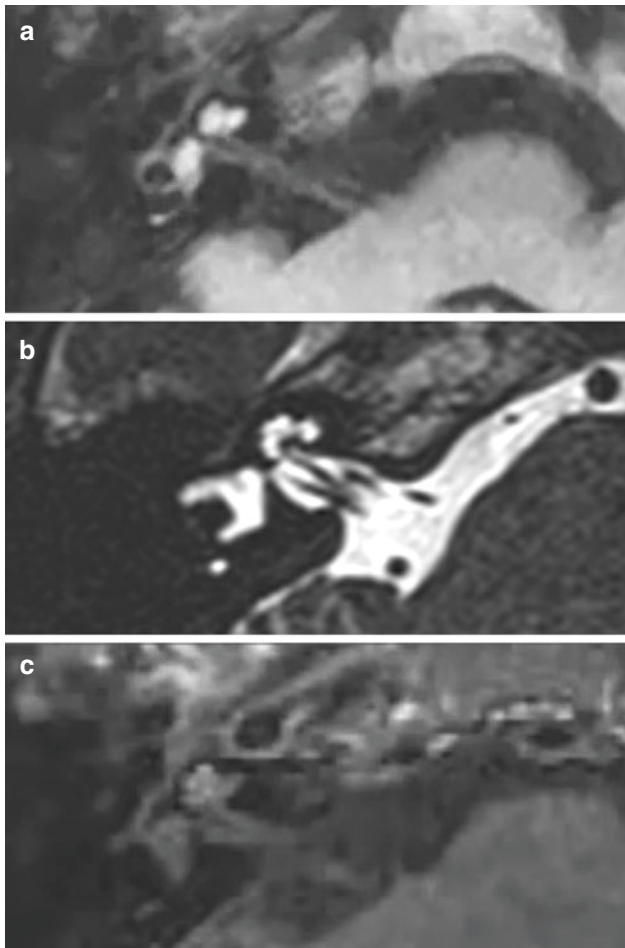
Three coplanar magnetic resonance imaging pictures of a patient with acute otitis media presenting with vertigo and profound hearing loss. (a) A T1WI with fat suppression and gadolinium MRI showing a cochlear and vestibular enhancement. (b) T2WI showing an isointense signal of the cochlea and vestibule in relation to the cerebrospinal fluid. (c) T2-flair imaging showing increased cochlear signal, suggestive of acute labyrinthitis
